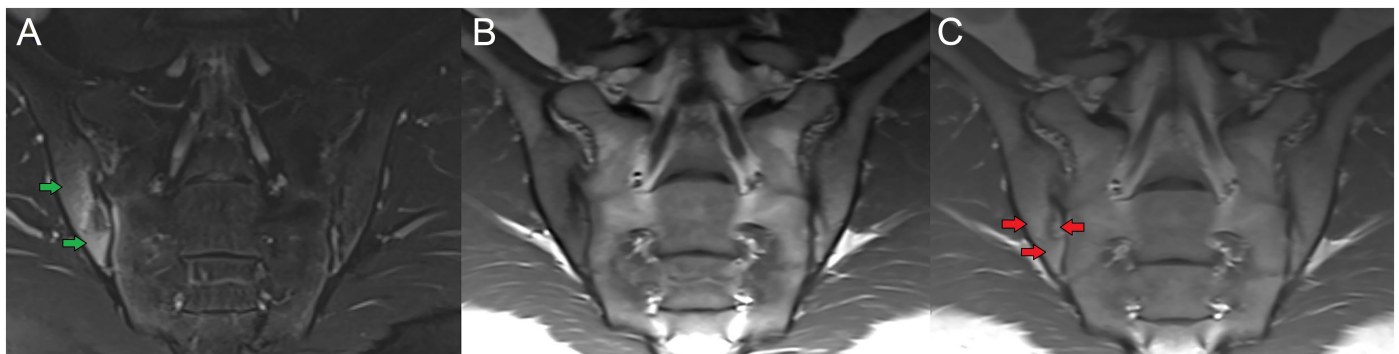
(A-C) Fat-saturated T2-weighted (A), nonenhanced T1-weighted (B), and enhanced T1-weighted (C) sacroiliac magnetic resonance images in the coronal plane indicate the unilateral involvement of the right sacroiliac joint. In addition, subchondral edema (green arrows) and contrast enhancement of the right sacroiliac joint (red arrows) was observed on the magnetic resonance images.
